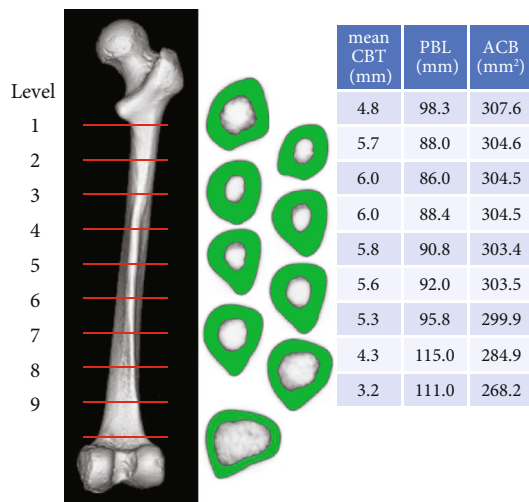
Example of results from the Late Jomon Period population. The shapes of cross-sections at eight levels are shown. In the table, the values for mean cortical bone thickness (mean CBT), periosteal border length (PBL), and the area of cortical bone (ACB) are shown. The image was composed with CT images using Radiant DICOM viewer (ver 2020 1.1 (64-bit), Mexidant, Poznan, Poland).
